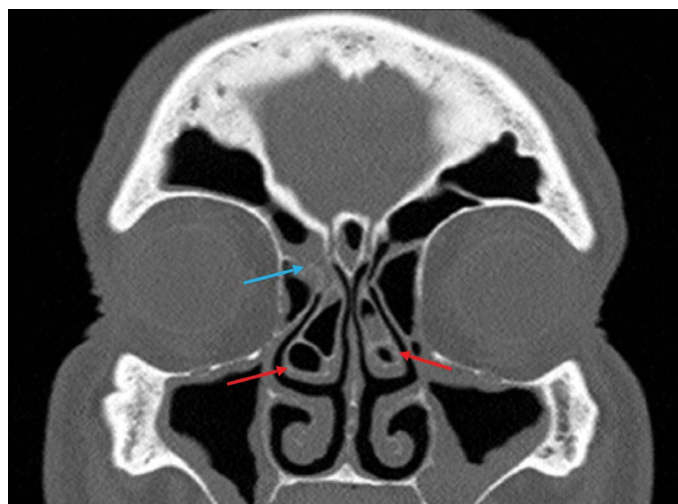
CT scan of sinuses in frontal projection. Visible swollen middle nasal concha, so-called 'concha bullosa' (red arrows), obstructed right-sided frontonasal duct (blue arrow) and maxillary sinus mucosal hypertrophy.
